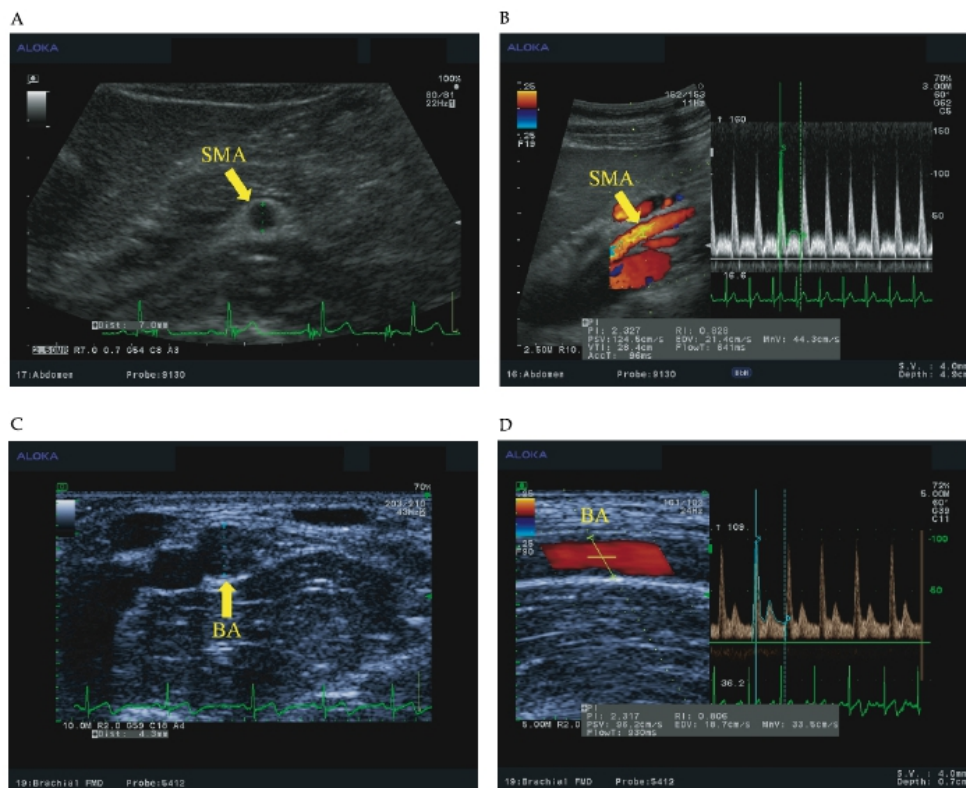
Haemodynamic data obtained by ultrasound. Vessel diameter of the superior mesenteric artery (SMA) (A) and the brachial artery (BA) (C) were measured in B-mode. Blood flow velocity of the SMA (B) and the BA (D) were obtained by pulsed Doppler.
